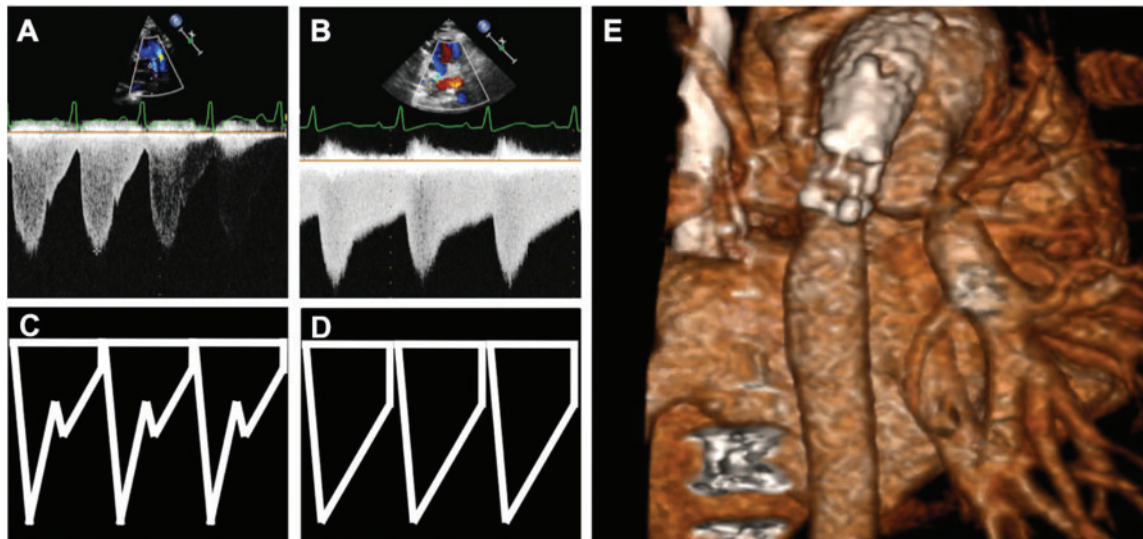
(A–E) Echocardiography after hybrid stage 1 palliation. Left pulmonary Doppler scan in the presence of restrictive foramen ovale (note trace is more 'pulsatile' than 'sawtooth') (A and C); left pulmonary artery Doppler scan after septostomy (note trace has regained 'sawtooth' pattern); (B and D) distal stent obstruction on computed tomography (E).
